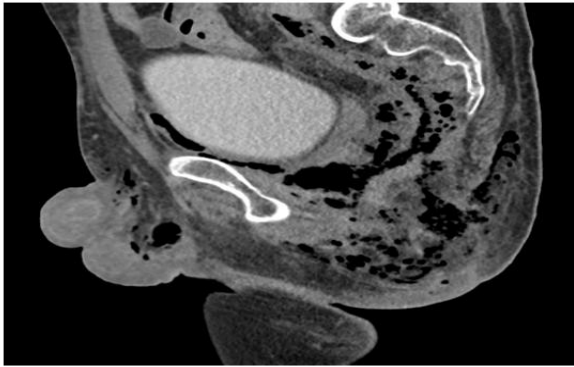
Sagittal views of pelvic CT with contrast at excretory phase confirms gas bubbles dissecting inside and outside the pelvis.
